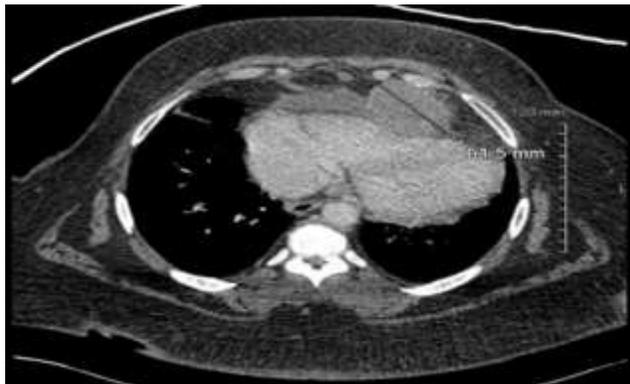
CT chest transverse section showing dominant pericardial mass.
